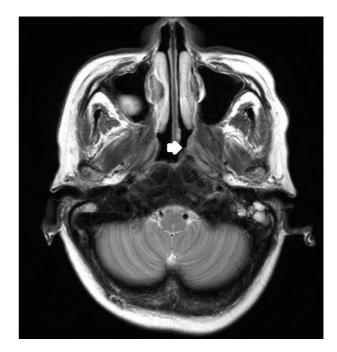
A T2 weighted MRI image showing an obliterated left Fossa of Rosenmuller with medialising left lateral wall of the nasopharynx (arrow).
